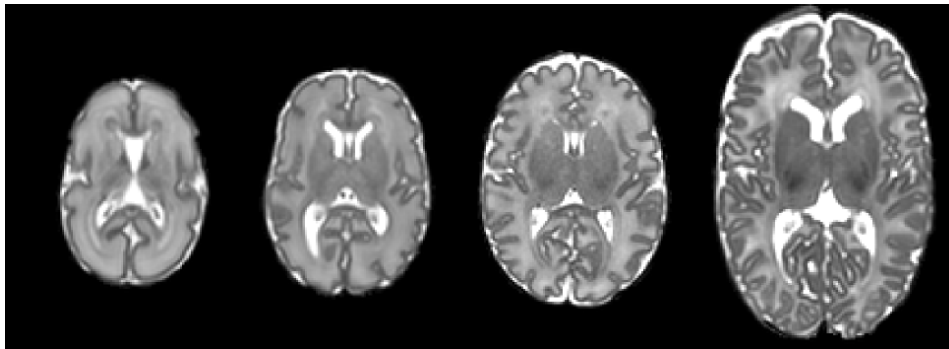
T2 MR images of the neonatal brain acquired at 28,32,36 and 44 weeks PMA (from left to right).
